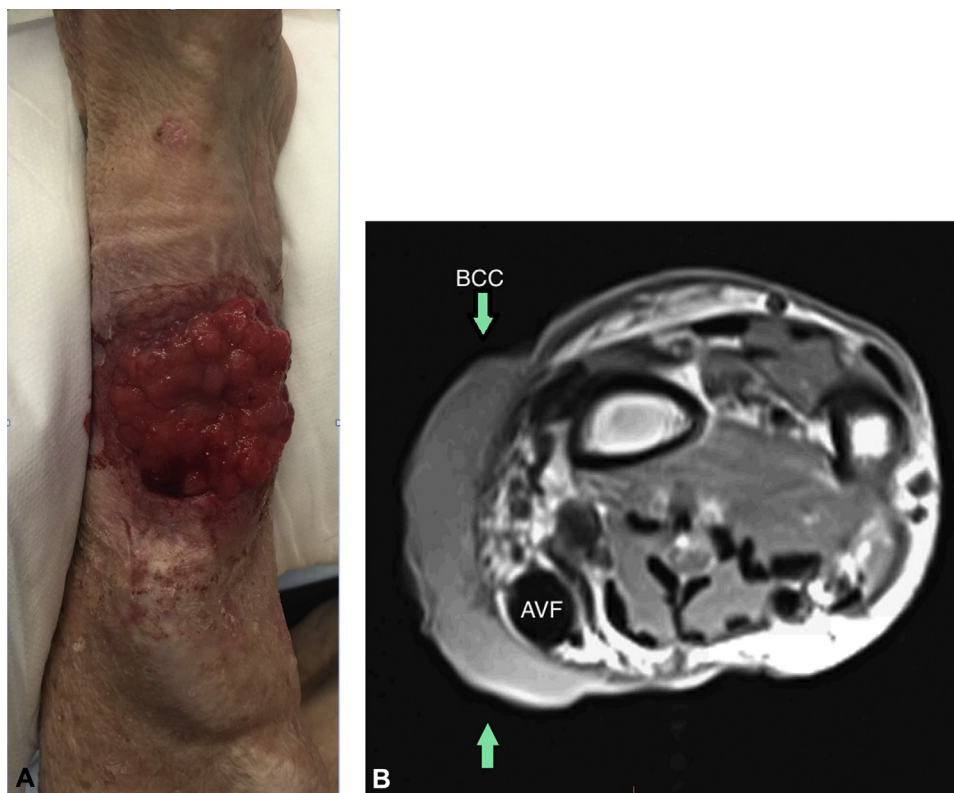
A, Clinical picture of basal cell carcinoma (*arrows*) of patient 2 before intraoperative AVF ligation and excision. B, Magnetic resonance image demonstrates a predominantly cutaneous and subcutaneous mass with proximity but no invasion of fistula. *AVF*, Arteriovenous fistula or graft.
